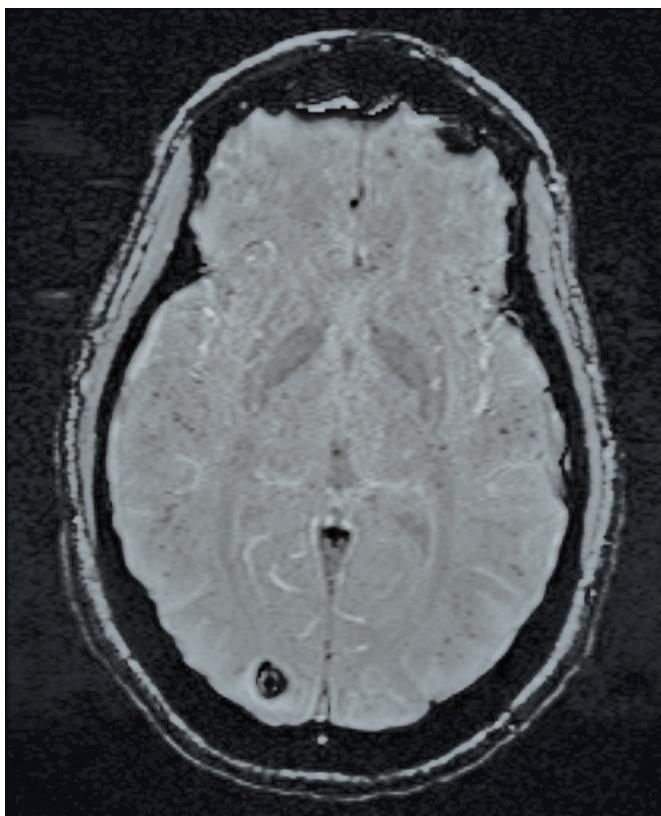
Magnetic resonance imaging performed on hospital day 14.
